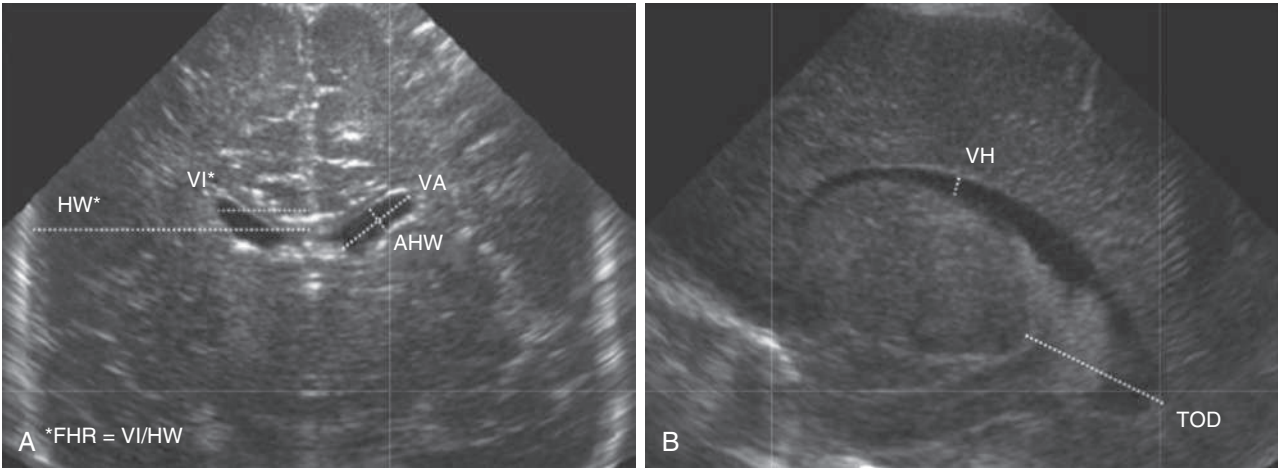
Ventricular parameters measured in the (A) coronal and (B) sagittal planes by cranial ultrasonography. AHW, anterior horn width; FHR, frontal horn ratio; HW, hemispheric width; TOD, thalamo-occipital distance; VA, ventricular axis; VH, ventricular height; VI, ventricular index. (From Brouwer MJ, de Vries LS, Pistorius L, et al. *Ultrasound measurements of the lateral ventricles in neonates: why, how, and when? A systematic review. Acta Paediatr.* 2010;99:1298–306.)
